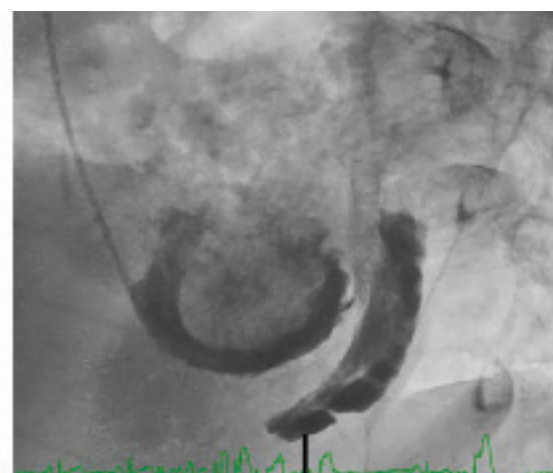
Frames from cine-ventriculography in right anterior oblique (RAO) projection (left image) and left anterior oblique (LAO) (right image) showing extravasation of radiographic contrast media into the left ventricular myocardium.
